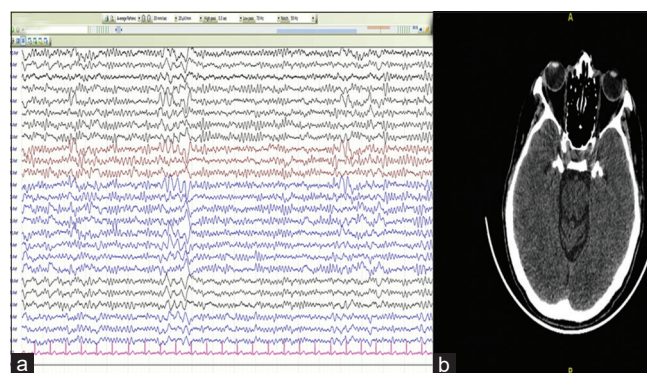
Investigation findings. (a) Electroencephalogram showing frontotemporal slowing in average referential montage. (b) Axial CT brain shows comma-shaped amygdalo-hippocampal calcification due to abnormal hyaline deposition in the capillaries
